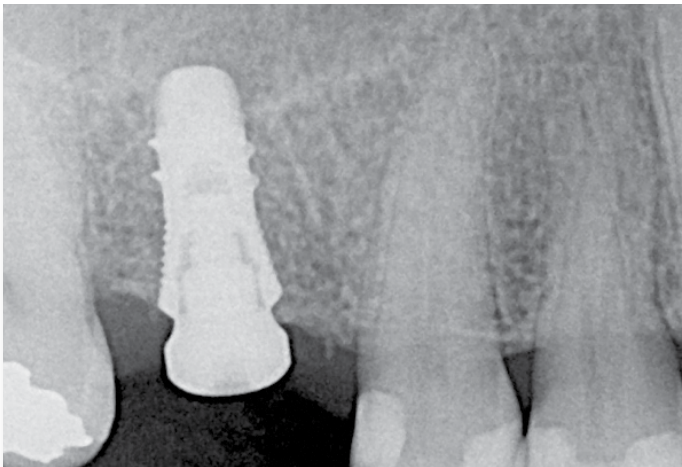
A radiograph of the Sybron Octa implant shows the position immediately after surgical placement. Note the platform-switching design of the healing abutment.
